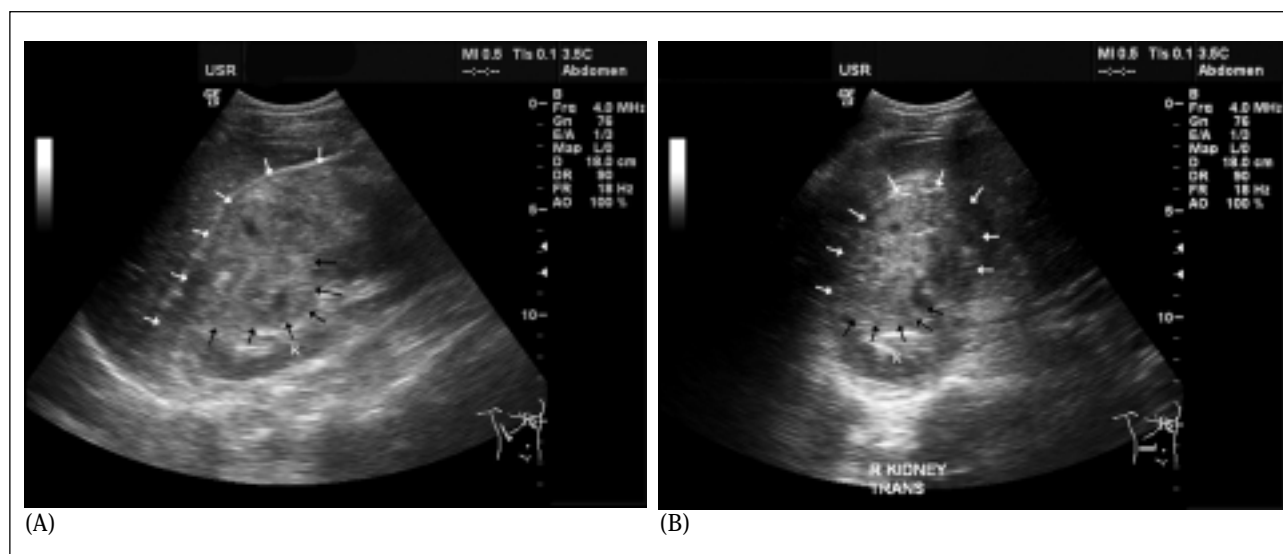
Sonographic scans of the right kidney (K) showing a huge perinephric haematoma (white arrows) extending from an anterior renal laceration (black arrows). A. Longitudinal scan; B. Transverse scan.
